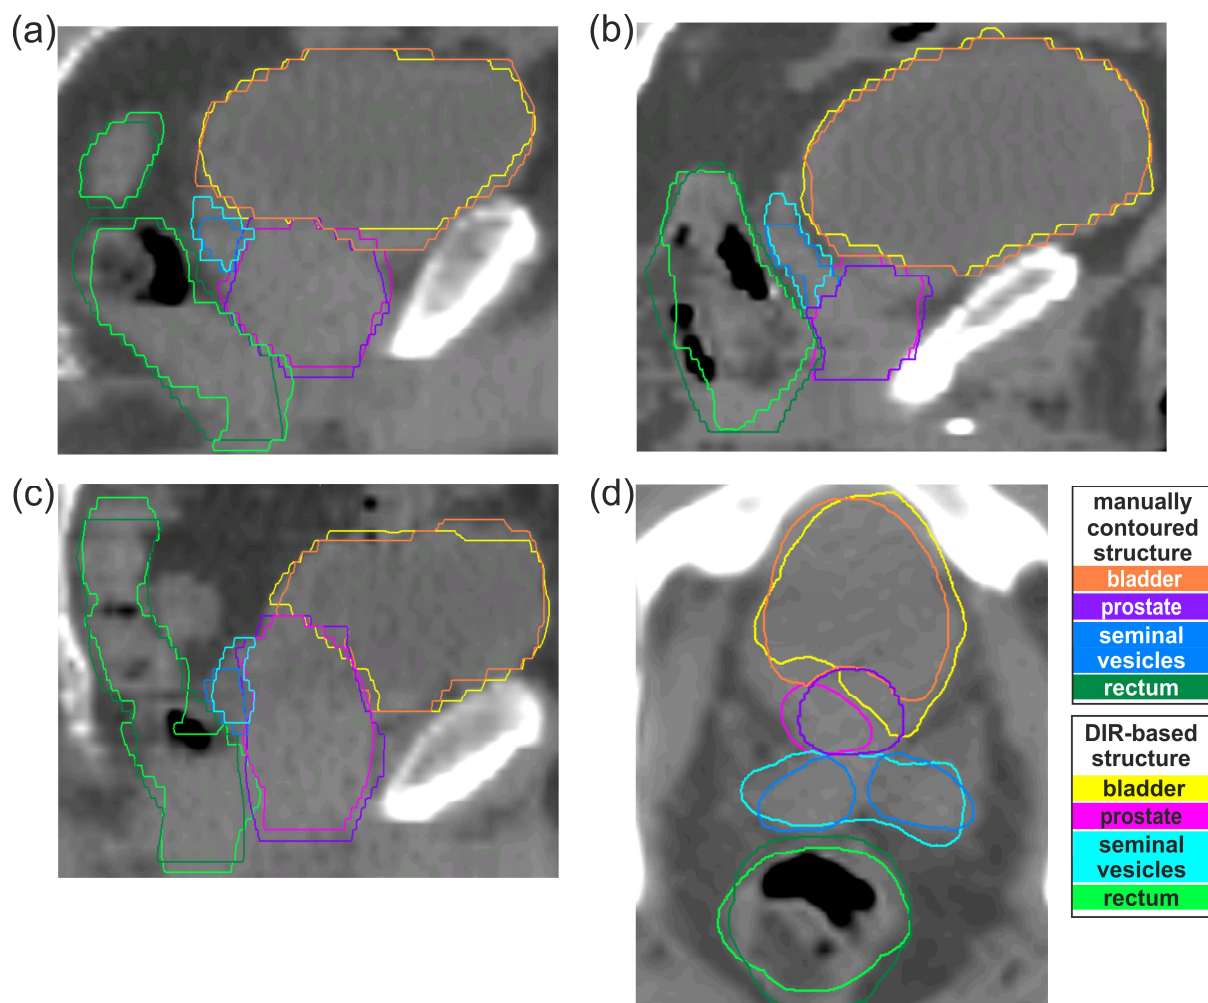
Sagittal slices with manually contoured and DIR-based generated structures for three exemplary patients ((a): P6, (b): P9 and (c): P14) on the first-fraction synthetic CBCT. Panel (d) contains a transverse slice of patient P9. For each of the two contouring sets, the four organ structures of the bladder, prostate, rectum and seminal vesicles are displayed.
